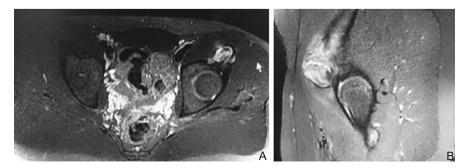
MRI-axial T1 showing hyperintense signal without any evidence of heterogenecity (A); MRI-saggital STIR showing hypertense signal on T2 without any evidence of heterogenecity (B).
